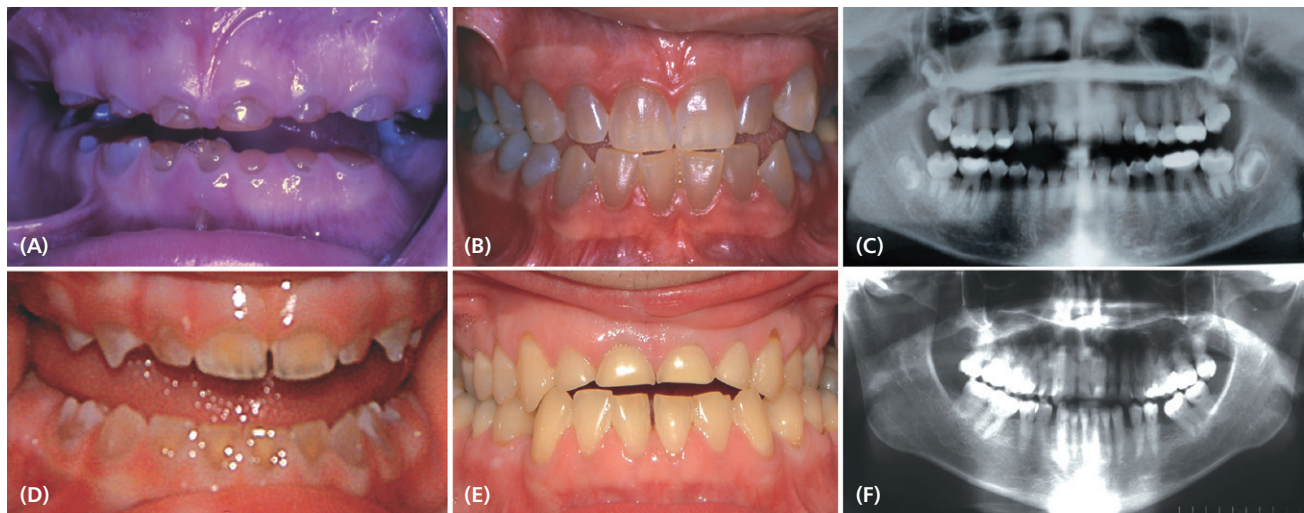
Phenotypic variations of patients with inherited dentin defects. Primary dentition (A), permanent dentition (B), and panoramic radiograph (C) of patient with DGI-II; primary dentition (D), permanent dentition (E), and panoramic radiograph (F) of patient with DD-II. Significant difference in the degree of discoloration between the primary and permanent dentition is evident in both conditions. Although a thistle-shaped pulp chamber with pulp stones is a hallmark of DD-II, complete pulp obliteration may take place over time after the eruption of permanent teeth in patients with DD-II, such as seen with the incisors (F).
